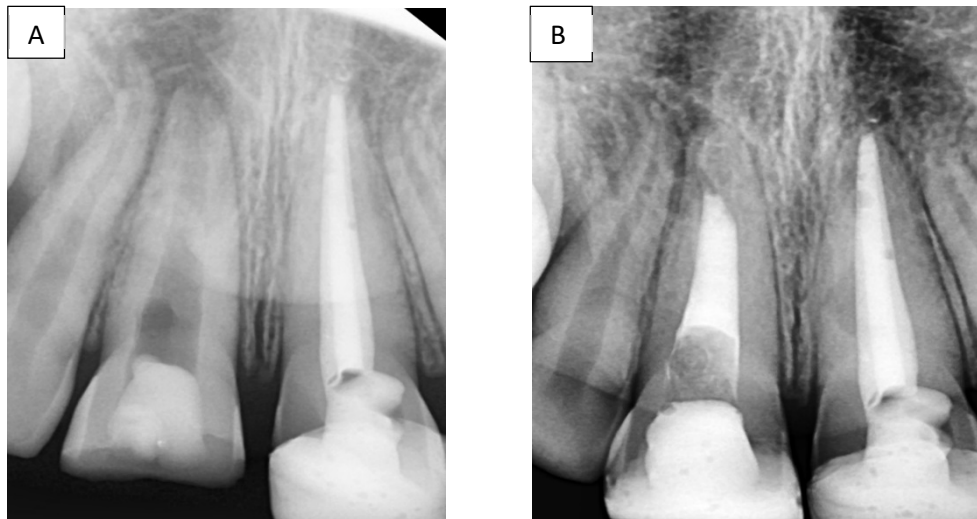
Treatment of traumatized maxillary right central incisor. (A) Pre-operative radiograph of the maxillary right central incisor (B) Twelve-month radiographic follow-up demonstrating the resolution of the periapical lesion with complete apical closure of the root
